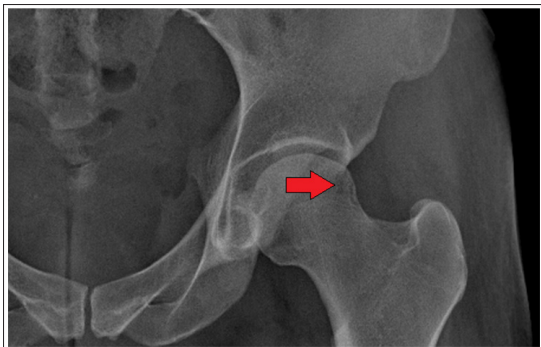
Anteroposterior radiograph of the pelvis showing subtle femoral head-neck asphericity and early acetabular changes on the left side (arrow), suggestive of femoroacetabular impingement morphology.
